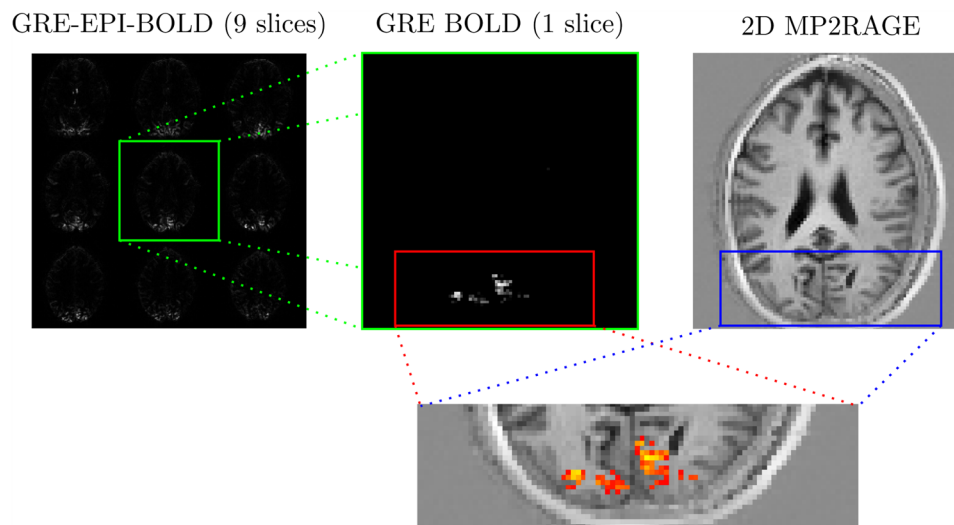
Exemplary functional and anatomical localization data from an oblique axial experiment. The left panel shows the activation estimate based on the Fourier analysis of GRE-EPI BOLD images. The middle panel shows a z-score map obtained using single slice SPGRE-BOLD. The right panel shows the T1-weighted anatomical matching the target slice. The bottom panel shows the z-score (>5) derived activation superimposed on the 2D adaptation of the MP2RAGE.
